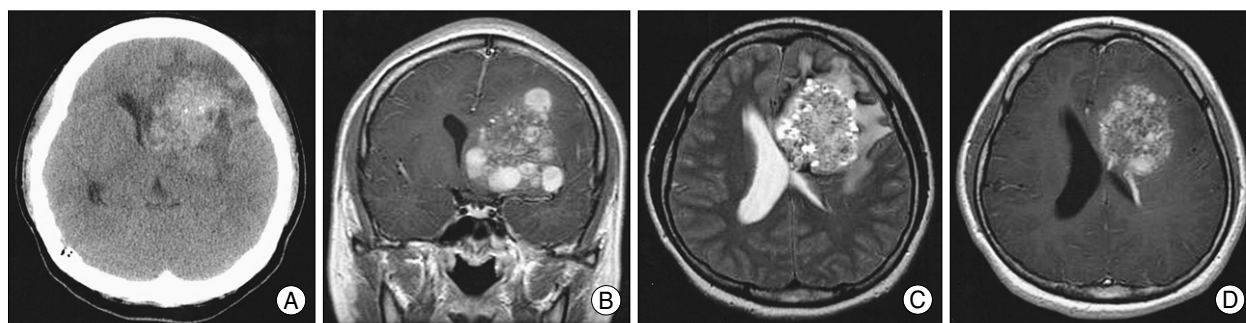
A : Non-enhanced computed tomography (CT) scanning showing a $7 \times 5 \times 5$ cm sized mixed density lesion with multifocal calcification in the left frontal and basal ganglia region. B, C : The mass was multicystic and mixed intensities on gadolinium-enhanced coronal magnetic resonance (MR) image (B) and surrounded by a low signal intensity rim on T2-weighted axial images (C), representing hemosiderin. D : On enhanced axial MR images, there was venous angioma abutting medial portion of the mass.
